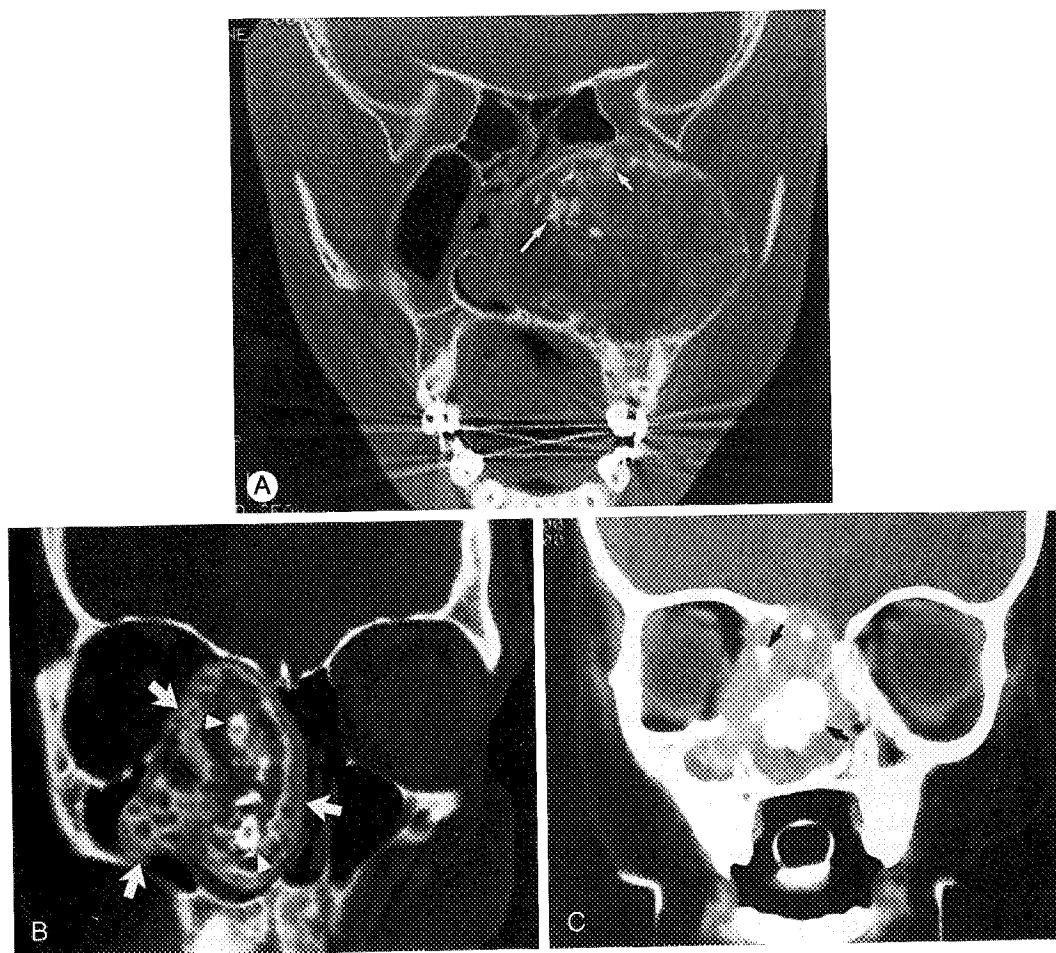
Aggressive psammomatoid ossifying fibroma. A, CT scan shows a large expansile mass of mixed intensity. Note psammomatoid bodies (arrows). B, CT scan in another patient shows an ossifying fibroma (arrows). The lesion is less aggressive than the lesion shown in A. Note CT appearance of psammomatoid bodies (arrowheads). C, CT scan in a 18-month-old child shows a soft tissue mass, with involvement of medial wall of the orbit as well as the roof of the ethmoid bone. Note intralesional islands of calcifications (arrows). Pathologic diagnosis was felt to be most consistent with aggressive fibro-osseous lesion (fibrous dysplasia versus ossifying fibroma). (Courtesy of Tony Peduto, MD, Westmead, Australia.)
